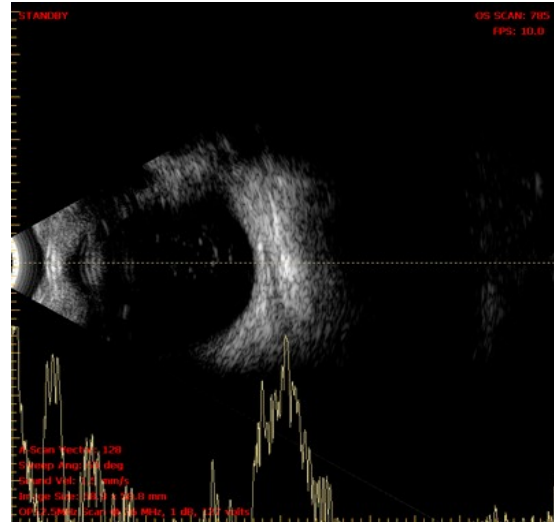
Ultrasound B scan showing intact globe with hypoechoic lesion on the cornea
